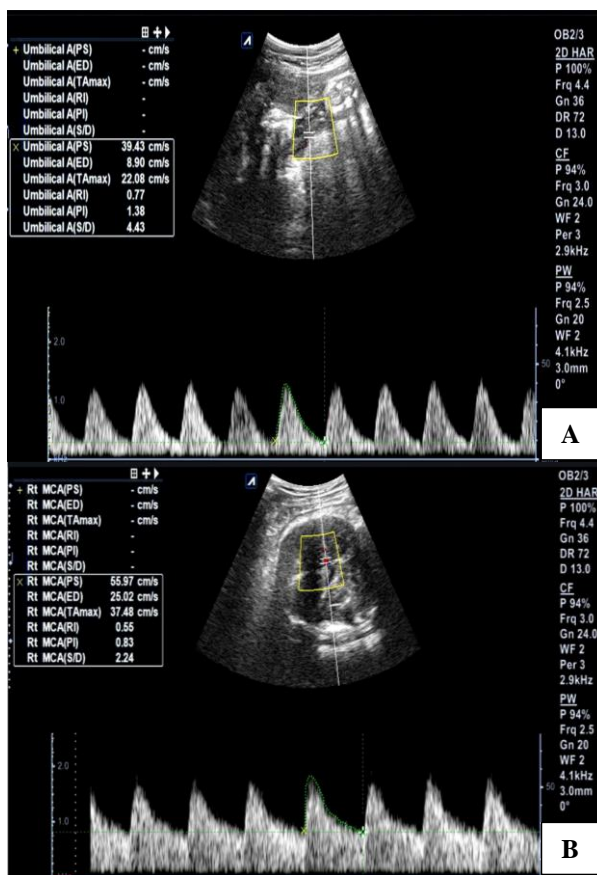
A 23 years old multigravida with gestational age 34 weeks 5 days with 4.1 g/dl Hb (severe anaemia) On Color Doppler ultrasonography (A) umbilical artery showed normal end diastolic flow and normal PI value; and (B) MCA PI value was decreased and on calculation cerebroplacental ratio was <1.
